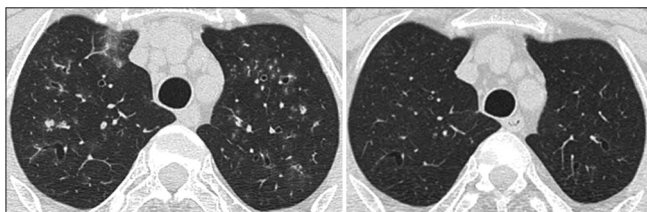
Axial images of CT chest taken a year apart shows resolving ground-glass opacities and centrilobular nodules in the follow-up CT images. The bronchial dilatation persists. (a) Image in 2019, (b) Image in 2020. CT: computed tomography, arrow: centrilobular nodules, arrowhead ground-glass opacities
